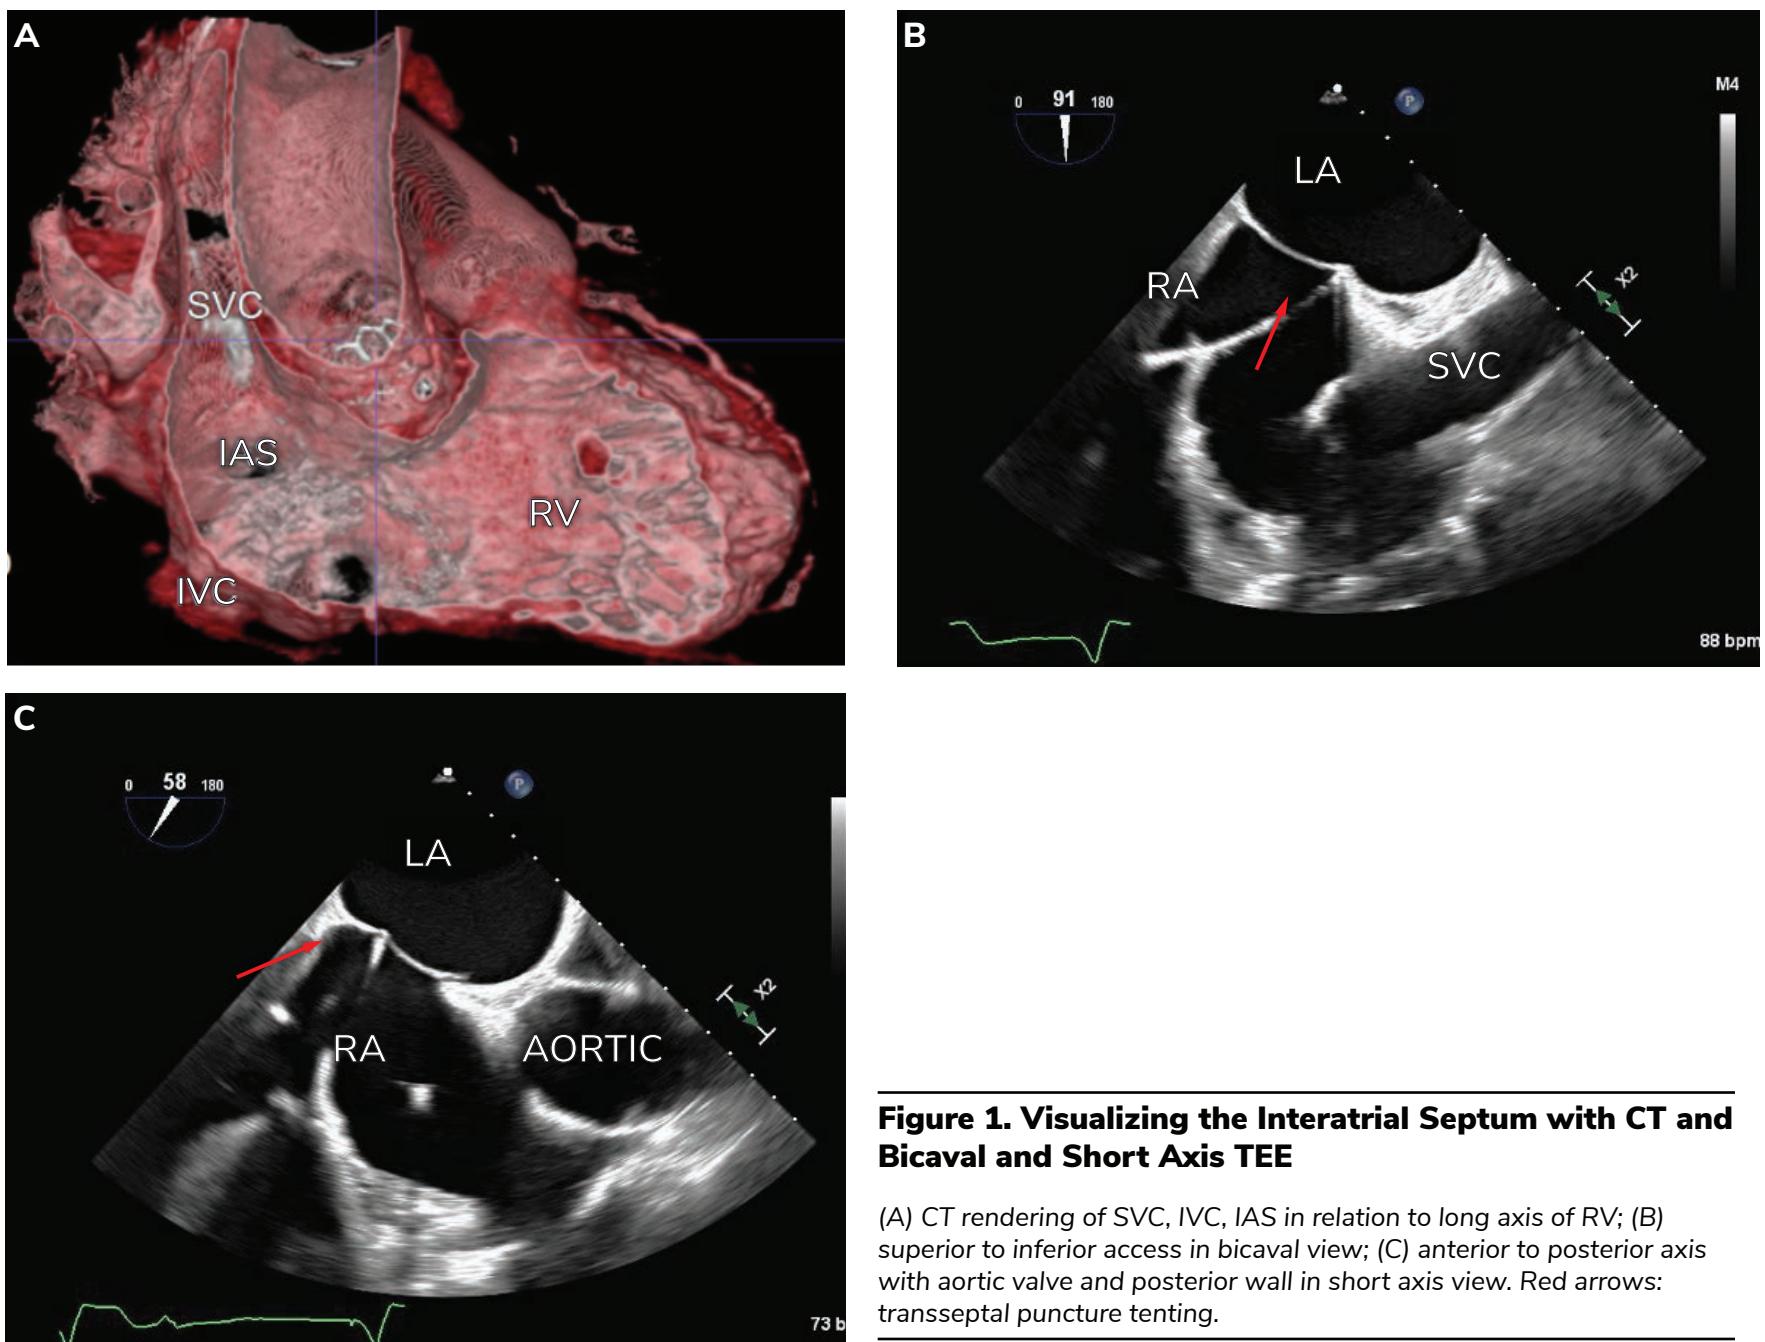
Visualizing the Interatrial Septum with CT and Bicaval and Short Axis TEE
